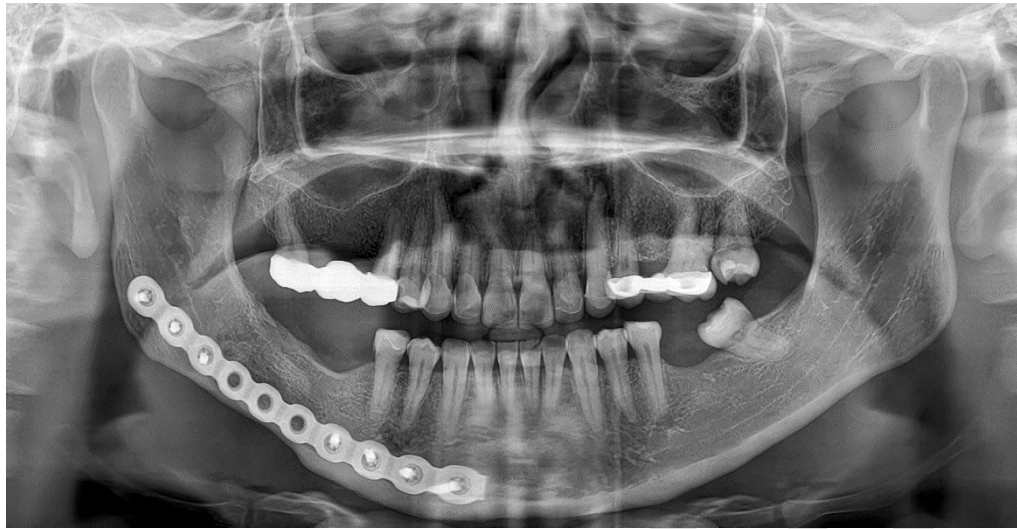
Panoramic radiograph taken six years after surgical treatment. Complete bone regeneration of the affected area is observed.
